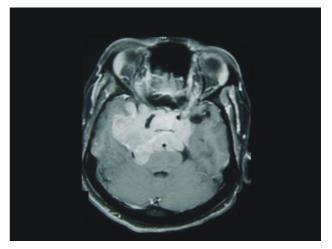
A-D. Grade IV pituitary adenoma. A. Coronal T1-weighted MR image, B. Coronal T2-weighted MR image and C. Post-contrast sagittal MR image show the encasement of anterior communicating artery complex within the tumor mass. D. Post-contrast axial MR image demonstrates the encasement of the basilar artery.
